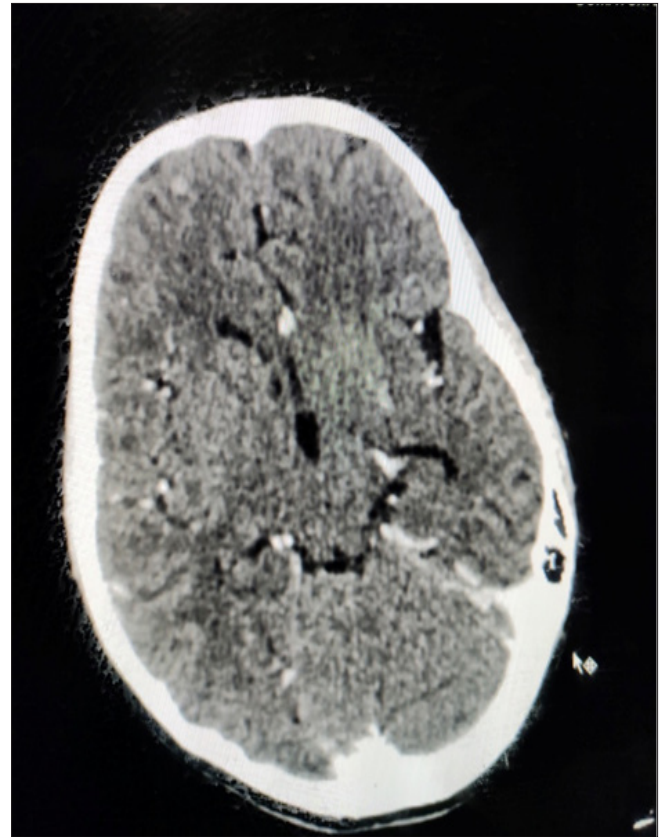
CT Brain Showing Tuberculoma
